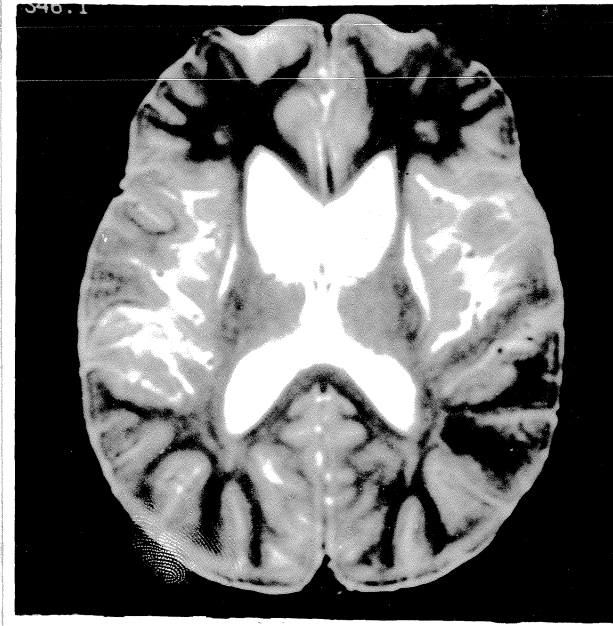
Bilateral caudate atrophy with frontal horn dilatation in a case of Juvenile Huntington's disease. (MRI T₂WI)
